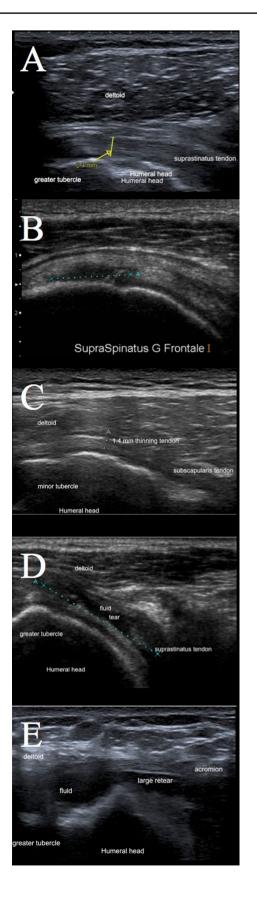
Integrity of the repaired rotator cuff classified into five types using ultrasonography; a type I indicates a repaired rotator cuff with sufficient thickness (>2 mm) with echostructure as normal tendon hyperechoic and fibrillar on each image; b type II indicates a repaired rotator cuff that had sufficient thickness (>2 mm) associated with a partial hypo-echogenicity or heterogenicity; c type III indicates a repaired rotator cuff that had insufficient thickness (<2 mm) without discontinuity; d type IV indicates the presence of a minor full-thickness discontinuity of which border is well visible, suggesting to a small tear; e type V indicates the presence of a major discontinuity of which the medial border is not visible under the acromial arch, suggesting a medium or large tear</p>
